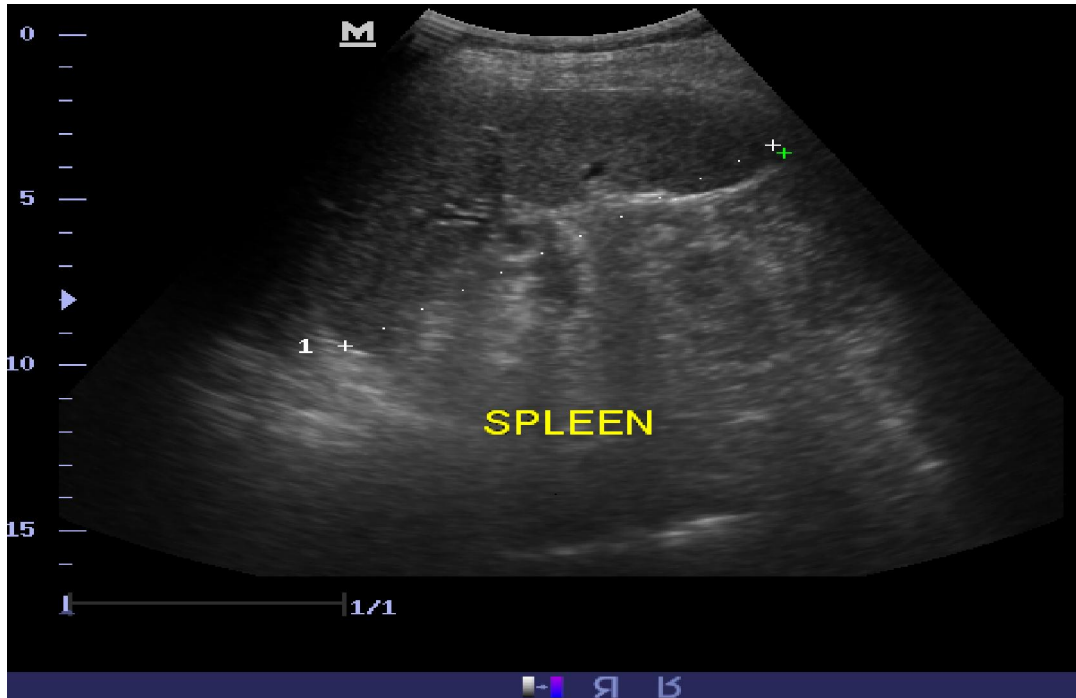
sonographic measurement of spleen span in MAL
